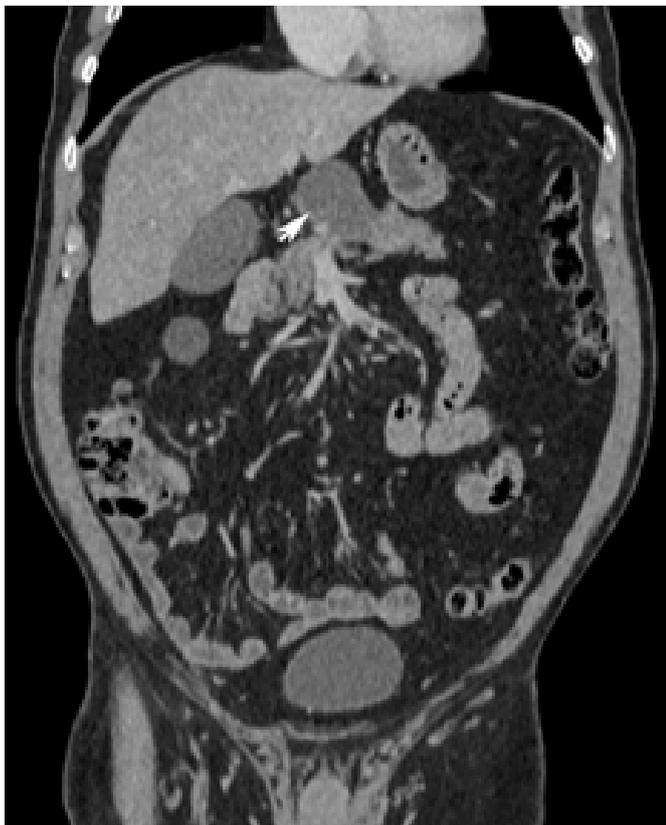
CT image of cyst (arrow) arising from the junction of the head and body of the pancreas.
